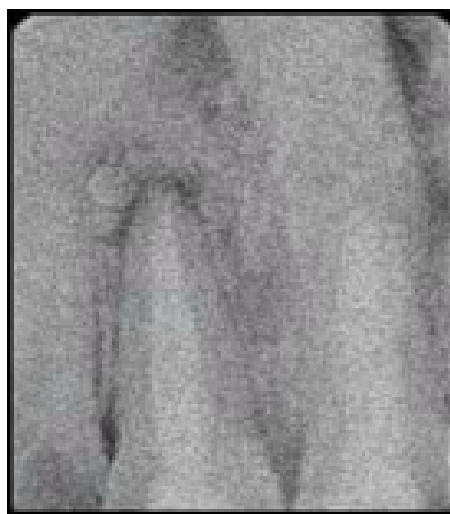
A post-operative radiograph at a 3-month follow-up showed a reduction in the size of the periapical radiolucency
